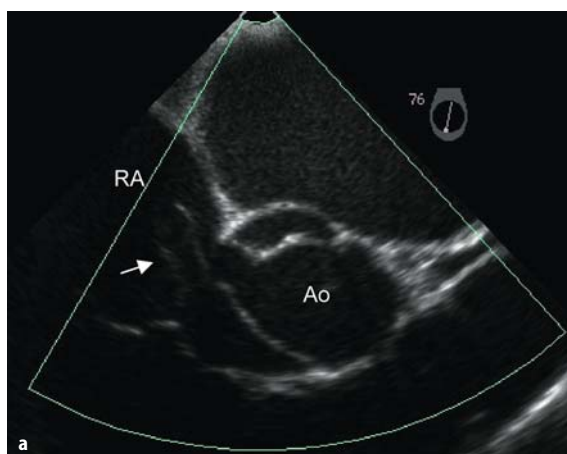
Aneurysm of the sinus of Valsalva. a Fingerlike expansion of the anterior-lateral part of the sinus (arrow) with disruption into the right atrium (RA). b Color Doppler flow of the shunt between the aorta (Ao) and the right atrium through disruption of the sinus
